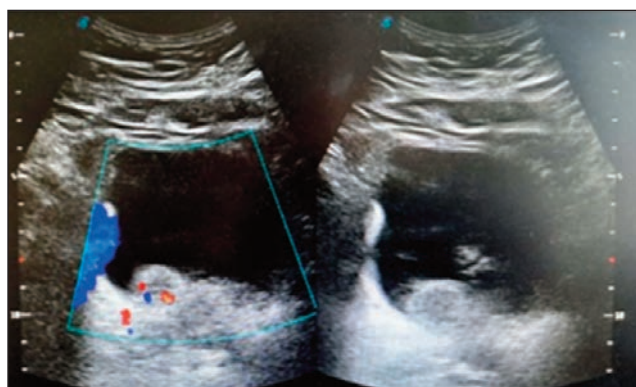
Ultrasound Image showing bladder growth.
